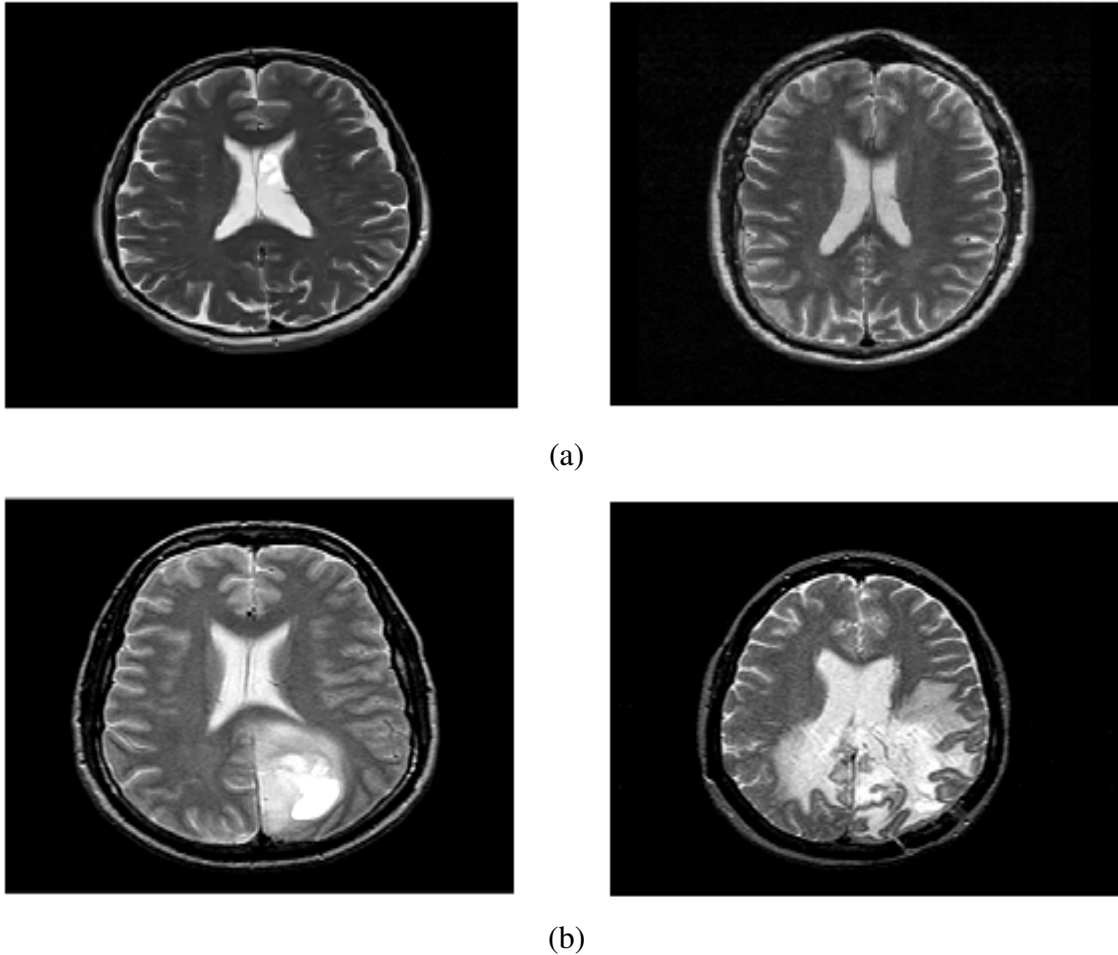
(a) Normal MRI images (b) Abnormal MRI images
